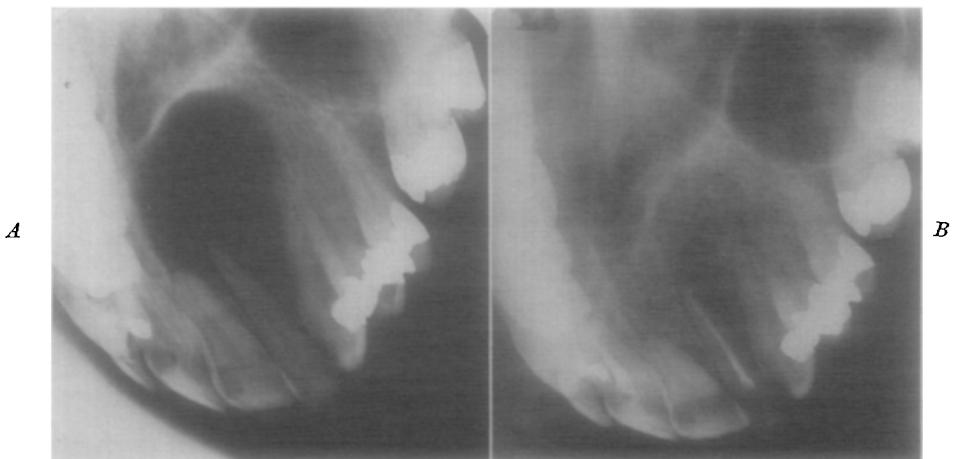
A*, Diagnostic occlusal roentgenogram of location and extent of lesion. *B*, Occlusal roentgenogram made 10 months after treatment was initiated.
